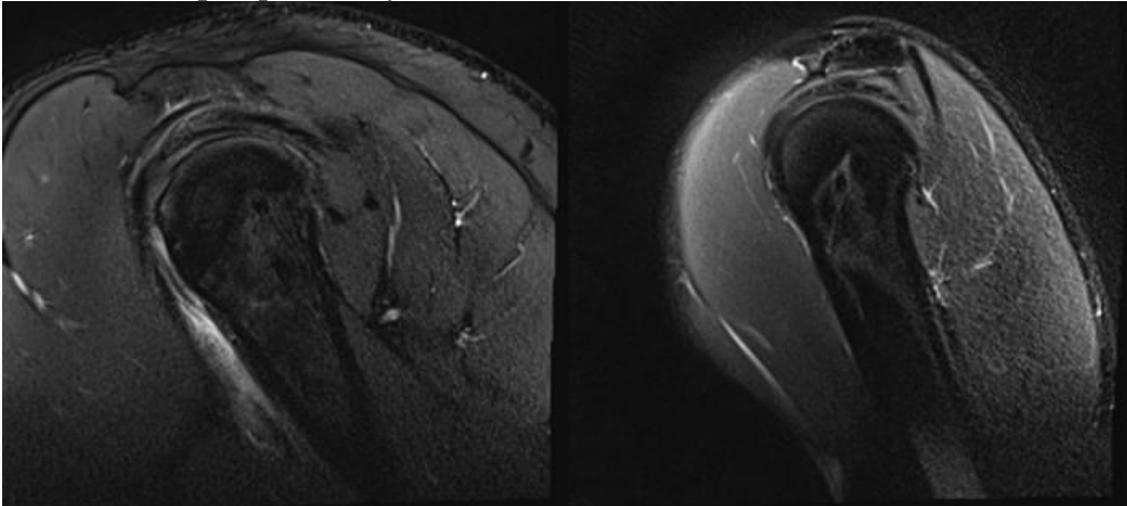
T2-weighted fat-suppressed image at the level of the distal insertion of the rotator cuff. Note the normal appearance of the rotator cuff at the distal most aspect of the tendons. The subacromial space is normal. There is no subacromial bursitis. No tear or tendinopathy is detected on this study.
